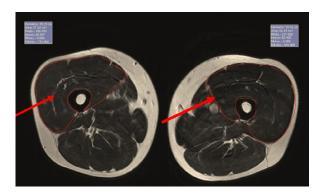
MRI of the quadriceps femoris muscle excluding bone and subcutaneous fat, with the arrows indicating the volumes circumscribed by the red lines in the limb with ACL injury (left) and contralateral limb (right) in the preoperative period.
